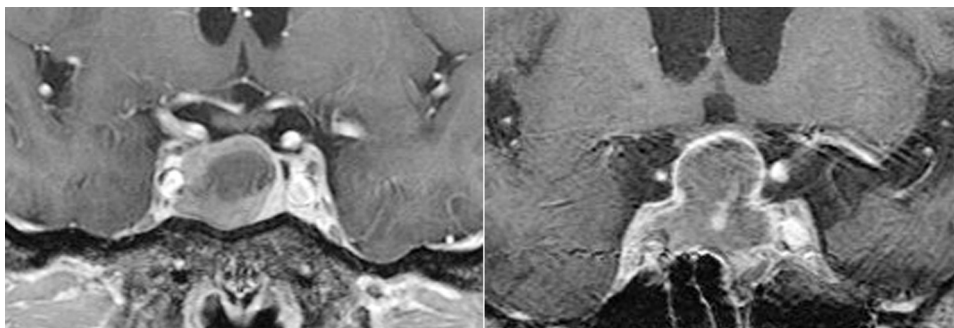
Coronal MR image of a patient with ischemic pituitary apoplexy showing a tumor in the sella turcica with homogeneous signal intensity, which had compressed the optic chiasm upwards (right). Coronal MR image of a patient with hemorrhagic pituitary apoplexy showing a tumor in the sellar turcica with homogeneous signal intensity (left).
